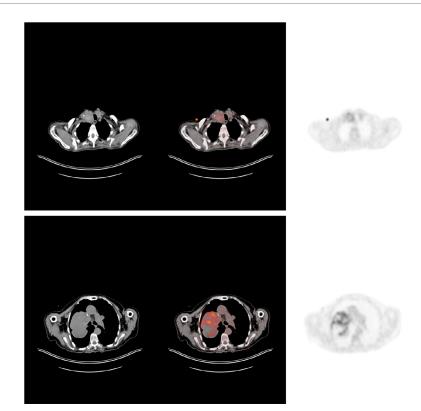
A 65 year old woman with the diagnosis of brain mass lesion was referred for FDG PET/CT imaging. The patient fasted for 10 hours before the imaging study and 7 mCi F-18 FDG was administered via venous line and waited for one hour. PET/CT imaging was performed in craniocaudal direction from head to feet with low dose noncontrast enhanced CT. The images showed postoperative changes in the brain region as well as mediastinal 100 mm (SUVmax=33.4) and left adrenal 36 mm (SUVmax=12.3) hypermetabolic mass lesions and bilateral thyroid nodules accumulating FDG (SUVmax=8.2)
